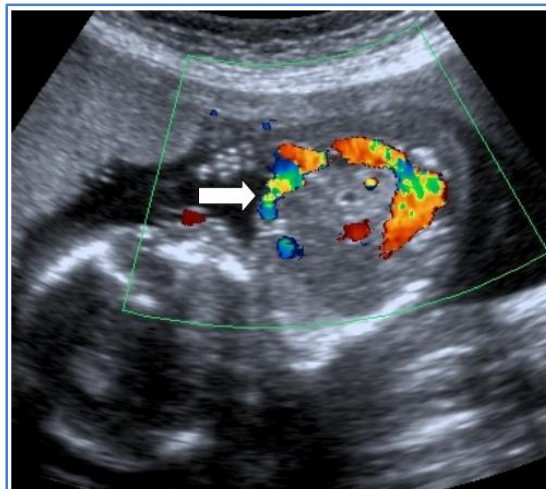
Shows color Doppler picture of umbilical vein draining in to Rt atrium
